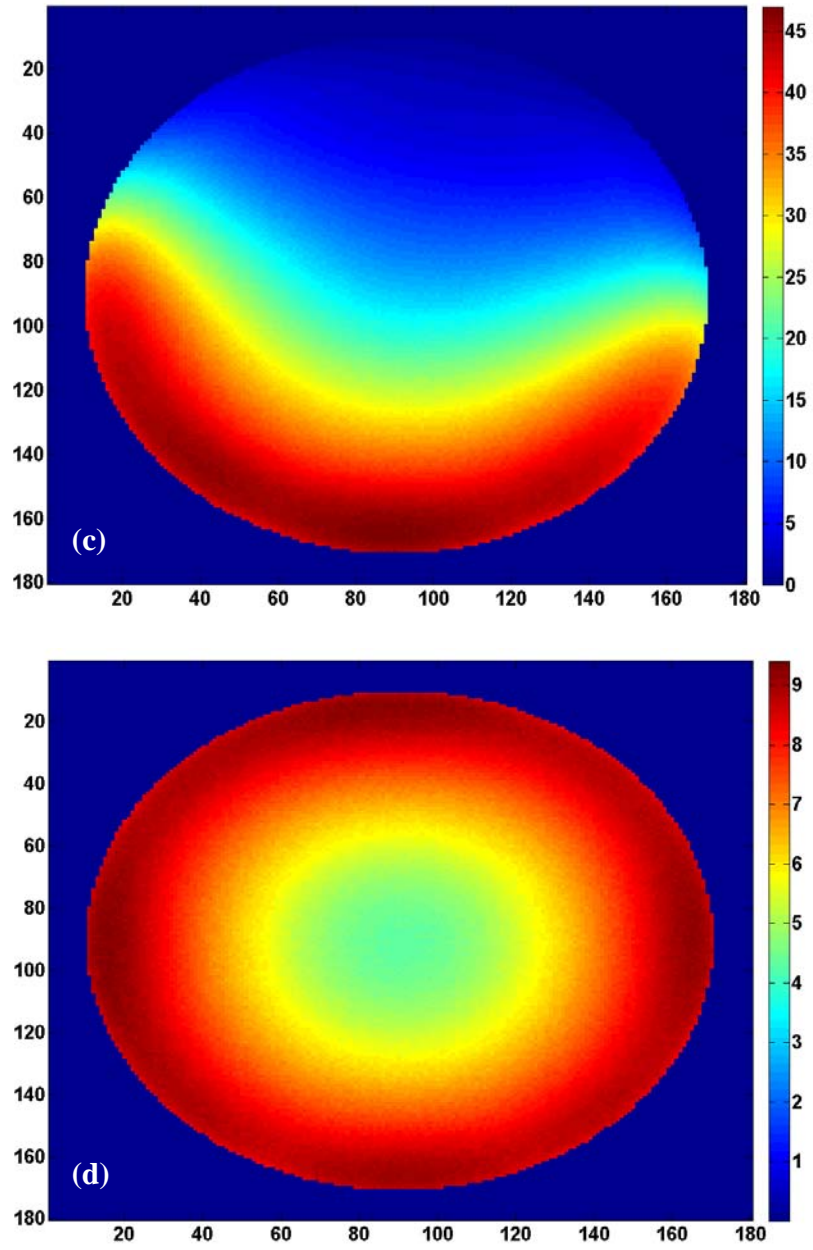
Visualization of the 2D dose distribution for each new CBCT scan protocol: (a) head, (b) pelvis, (c) pelvis spotlight, and (d) low-dose thorax scans.
